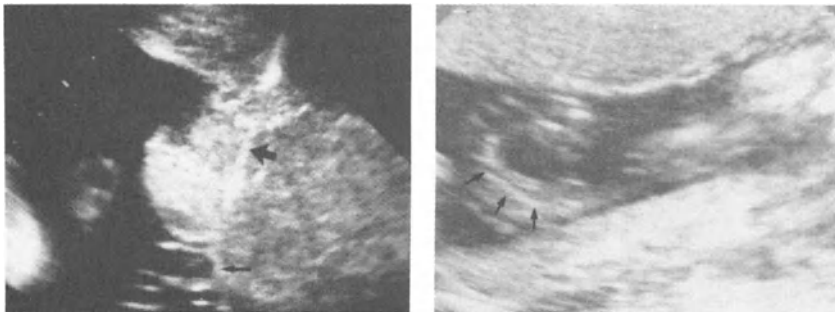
Ultrasound showing (A) the needle tip within the umbilical vein and (B) turbulence within the umbilical vein during transfusion.
